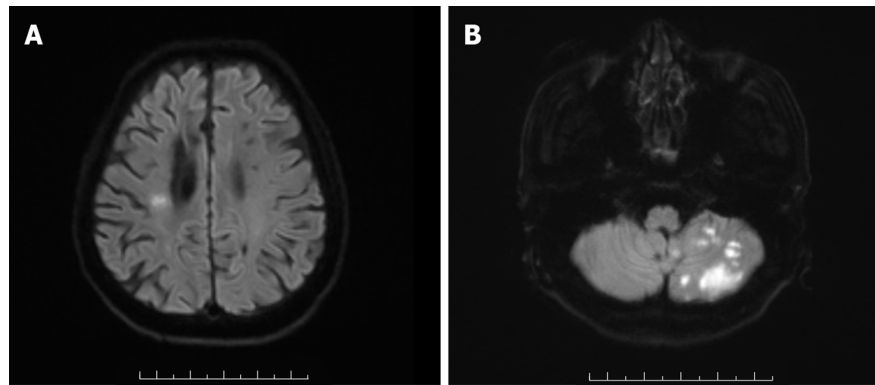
Magnetic resonance imaging images of the infarct location of the patient with cerebral infarction. A: Patient with anterior circulation infarction; B: Patient with posterior circulation infarction.
